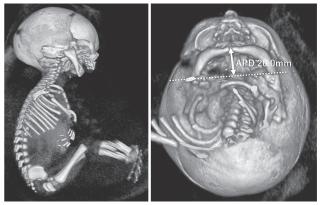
In the fetal 3D-CT examination, mandibular hypoplasia and fusion of the humerus, radius and ulna were observed, along with a thumb fracture.
